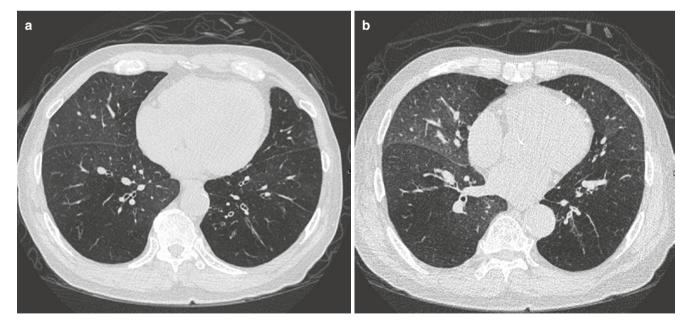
Small airways disease. (a) Inspiratory image shows mosaic attenuation with small caliber vessels in lucent zones and large airways disease (bronchial wall thickening). (b) Expiratory CT image shows no
